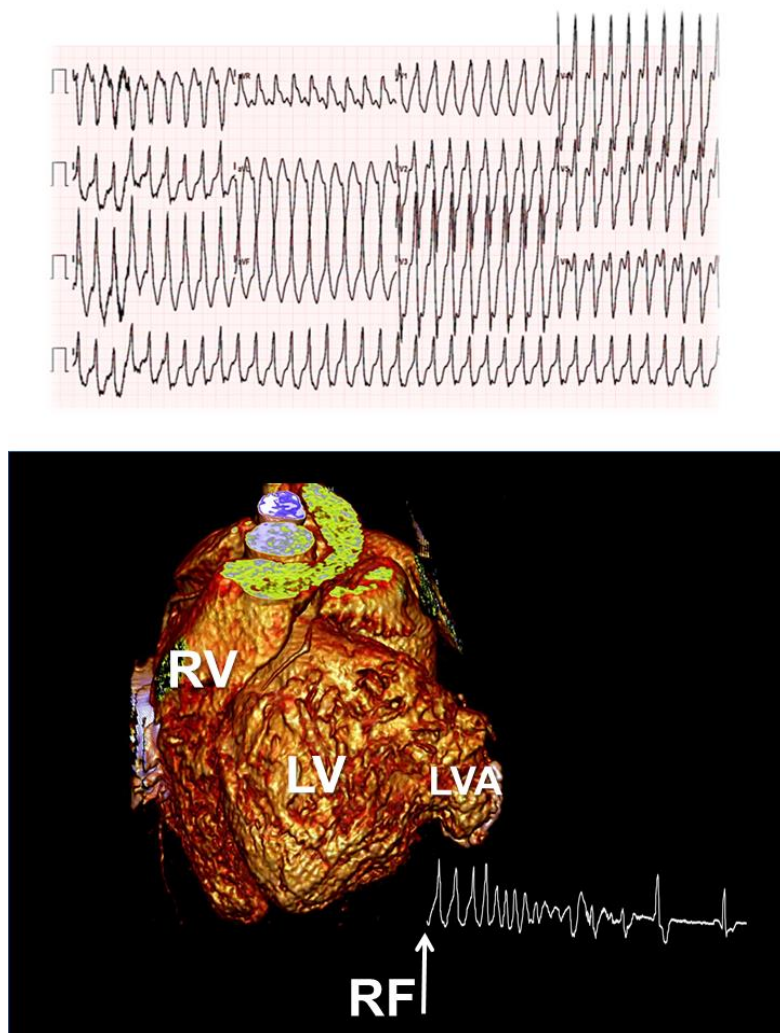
Catheter ablation of a VT in a 19-year-old male patient with a surgically corrected congenital left ventricular aneurysm (LVA), an ICD and recurrent VT. Surgical resection of an aneurysm in the basal posterior wall of the left ventricle was performed 10 years ago. A recurrence of the LVA was discovered during echocardiographic examination only one year after cardiac surgery. Eight years later, he developed non-sustained VT which progressed to sustained VTs within 3 years. Mapping during VT revealed the earliest activation relative to the onset of the QRS complex within the aneurysm. The VT terminated during RF application (RF). RV = right ventricle, LV = left ventricle, LVA = left ventricular aneurysm.
